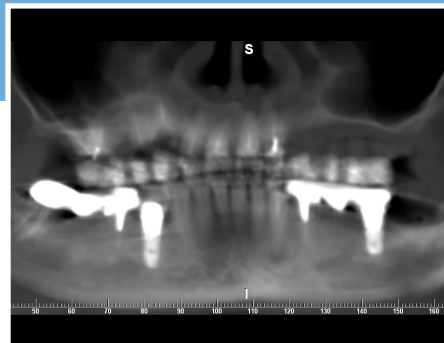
Preoperative panoramic CT scan showing the residual dental elements and the anatomy of the maxillary sinuses.
